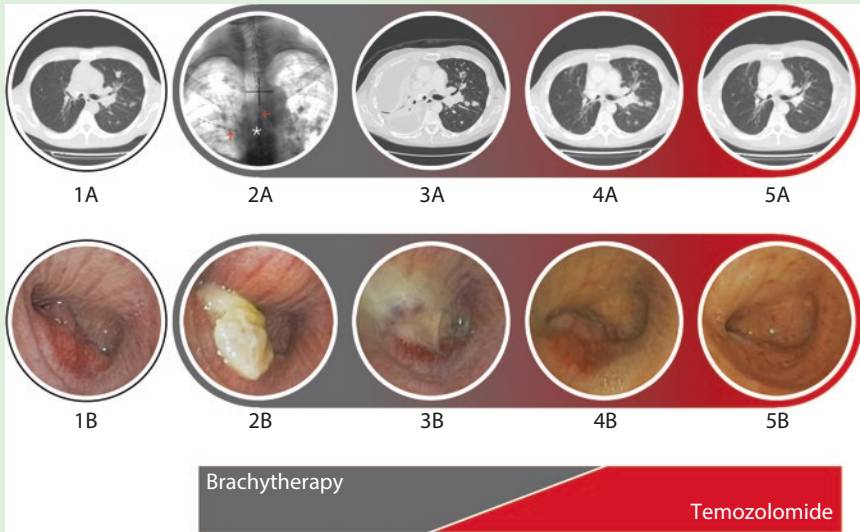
The CT scan initial appearance of the carcinoid tumour (Fig. 19.1 panel 1a) shows a metastatic spread in both lungs and an endobronchial recurrence of the typical carcinoid in the stump of the bronchus intermedius (Fig. 19.1 panel 1b). Furthermore the endoscopic view of the carcinoid tumour (Fig. 19.1 panel 1b) was surrounded by capillary web particularly on the cartilaginous part of the main right bronchus mucosa (arrow). After the first fraction of brachytherapy (Fig. 19.1 panel 2a, arrows on the two beads of the centring intraluminal guide probe, asterisk, whereas the HDR field was performed), the endobronchial lesion increased in volume due to the necrotic tissue (Fig. 19.1 panel 2b). At the third fraction of BT, the right lung was completely atelectatic (Fig. 19.1 panel 3a) with fibrous tissue occluding completely the lumen of the bronchus for the right upper lobe at the endoscopic view (Fig. 19.1 panel 3b). Furthermore decreased extension of the capillary web, covered by white induitus of fibrin, was fairly present (Fig. 19.1 panel 3b arrow). During this period chemotherapy with TMZ was started (red fading field). At the 6-month period after the initial TMZ treatment, the endobronchial lesion shrinks 20% (Fig. 19.1 panel 4b) with a slight decrease of the previously described capillary area (arrow). At the CT scan was clearly evident the re-expansion of the right upper lobe (Fig. 19.1 panel 4a). Control after 1 year of treatment shows a reduction in size and numbers of the lung metastatic lesions (Fig. 19.1 panel 5a) and a complete disappearance of the endobronchial lesion as well as the capillary web on the cartilaginous part of the main right bronchus (Fig. 19.1 panel 5b arrow)
